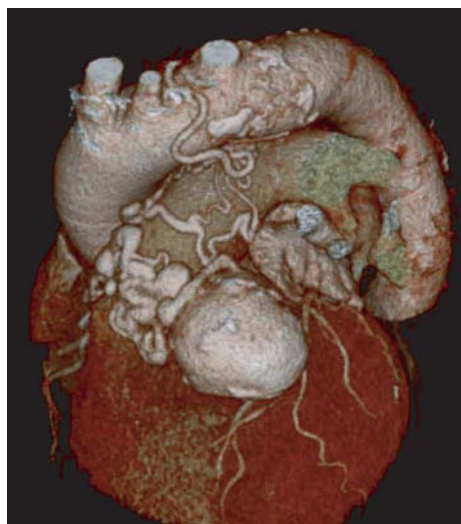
Contrast-enhanced 16-slice CT coronary angiography with 16×0.75 -mm collimation. Visualization of the left heart anatomy with 3D VRT reveals a complex and large fistula arising from the LAD and connecting to the ascending aorta. (Case courtesy of Hong Kong Sanatorium Hospital, China)
